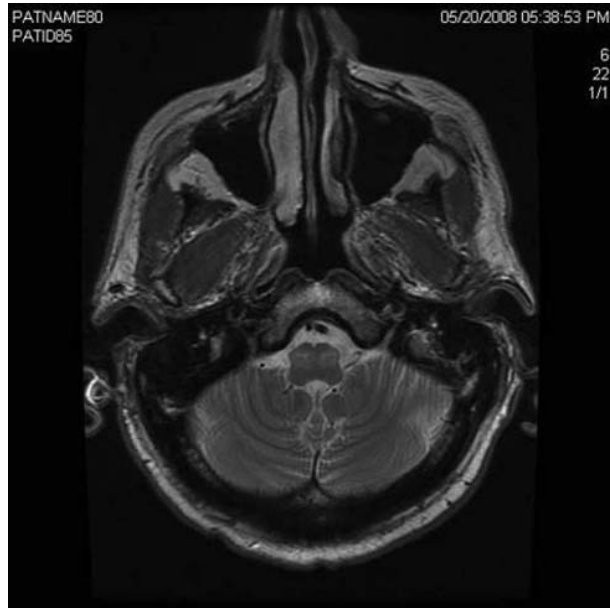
MRI showing modest bilateral degenerative hypertrophy of the inferior olive.
